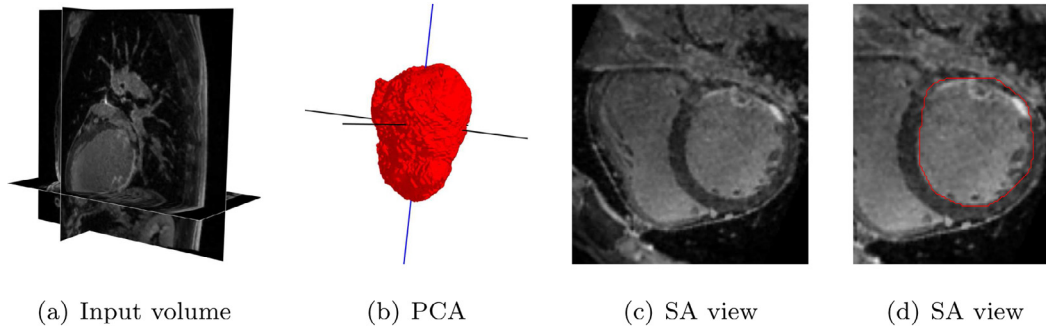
(a) 3-D LGE-MRI of the three orthogonal imaging planes, sagittal, coronal and axial. (b) Approximated cavity of the LV through the registration to the atlas data. The principal components are visualized, with the first principal component in blue and the second and third principal components in black. (c) Cropped pseudo short axis view after the principal component analysis. (d) Short axis view with the contour of the transformed mask in red. (For interpretation of the references to color in this figure legend, the reader is referred to the web version of this article.)
